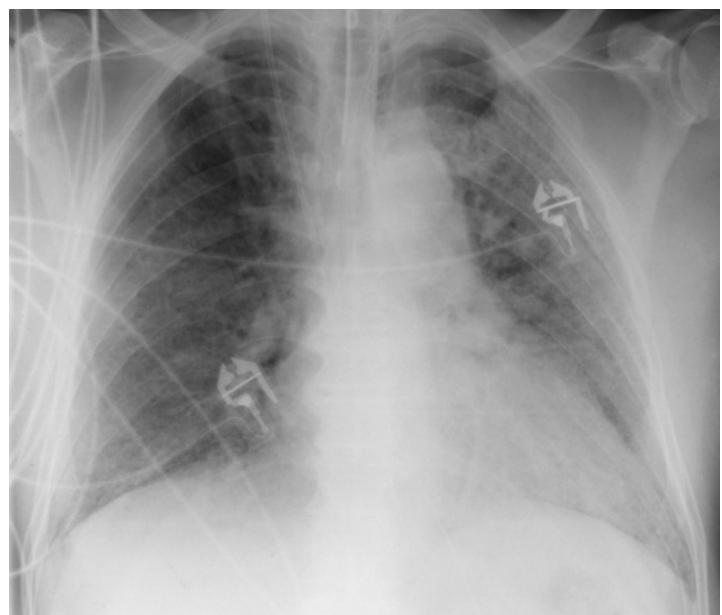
Pattern of ground-glass opacities in alveolar proteinosis. The film shows extensive, partially confluent area densities, appearing as ground-glass opacities in the peripheral areas. Left heart enlargement without any significant effusion. Radiograph obtained after intubation.
